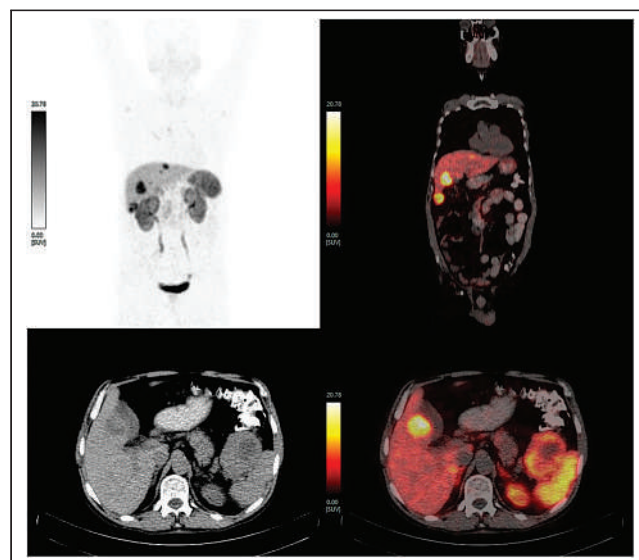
Baseline ^{68}Ga -DOTATATE PET/CT (upper left: maximum-intensity projection image; upper right: fused coronal; lower left: transaxial CT only; and lower right: fused transaxial) showing multiple SSTR-expressing hepatic metastases (liver segment V lesion).
